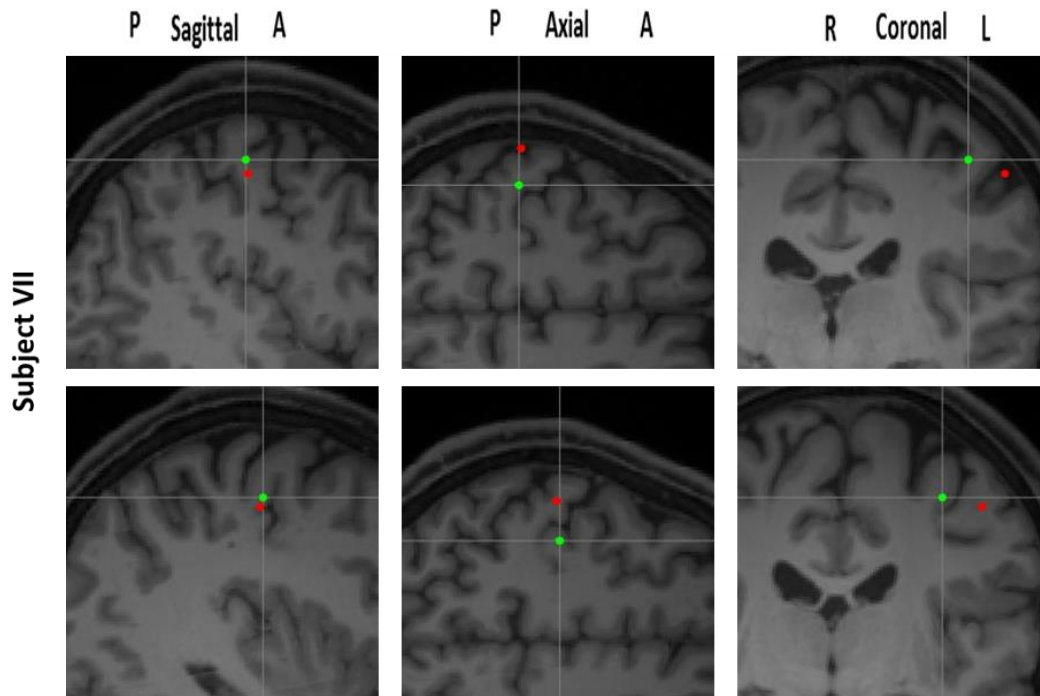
7 | Impact of different MEG/MRI co-registration methods on dipole location for somatosensory evoked fields for different subjects. The dipole locations for the different registration methods (red: SBM and green: SBM) are plotted on T1w-MRI slices. The dipole location based on the single shell was used for MRI slice selection and the other dipole was projected onto these slices. The dipoles for both, the single shell head model (upper row) and single sphere head model (bottom row) are depicted.
